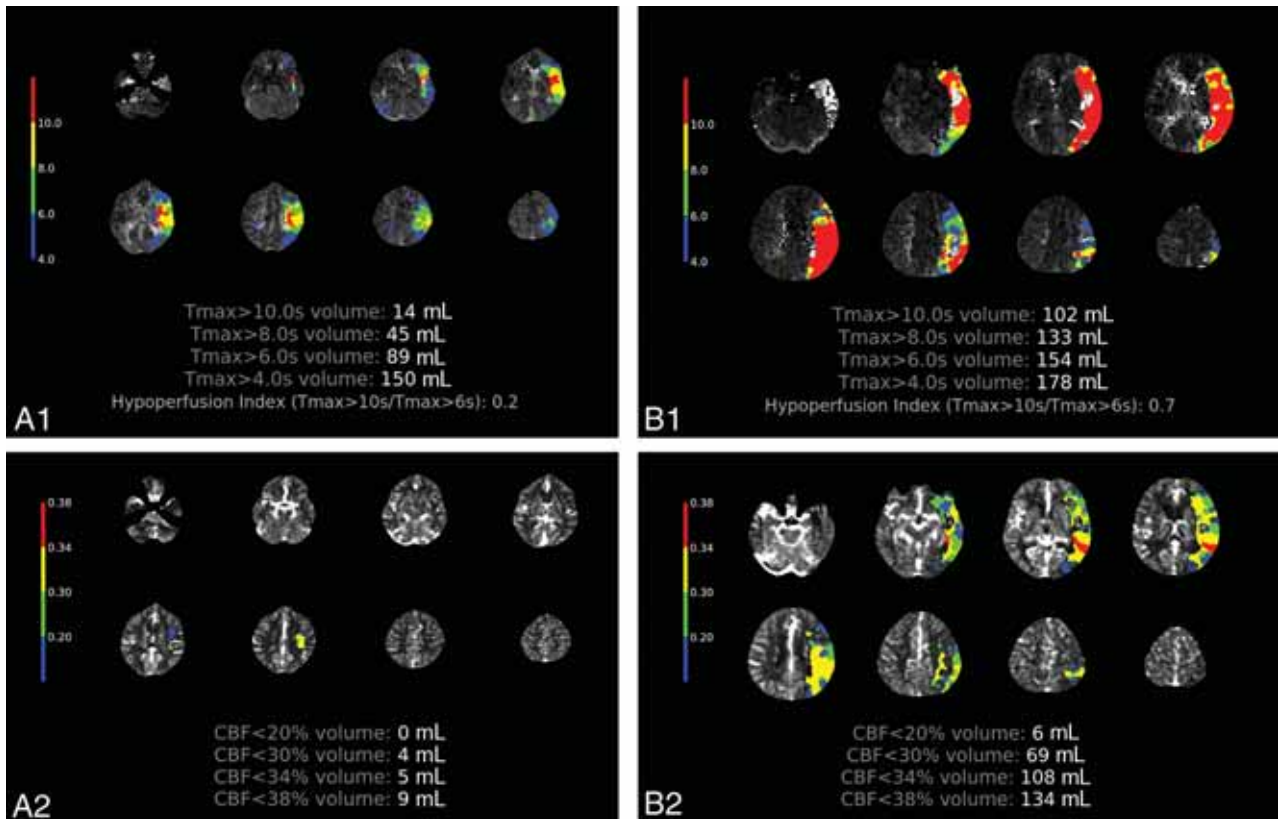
Tmax maps (A1 and B1) and CBF maps (A2 and B2) for 2 patients with either good (patient A, left column) or poor collateral supply (patient B, right column). Tmax lesion sizes, HIR, and CBF lesion sizes are all considerably smaller for patient A with good collateral supply compared with patient B with poor collateral supply. See Fig 1 for the corresponding noncontrast CT, CTA, and dynamic CTA for the same patients.
